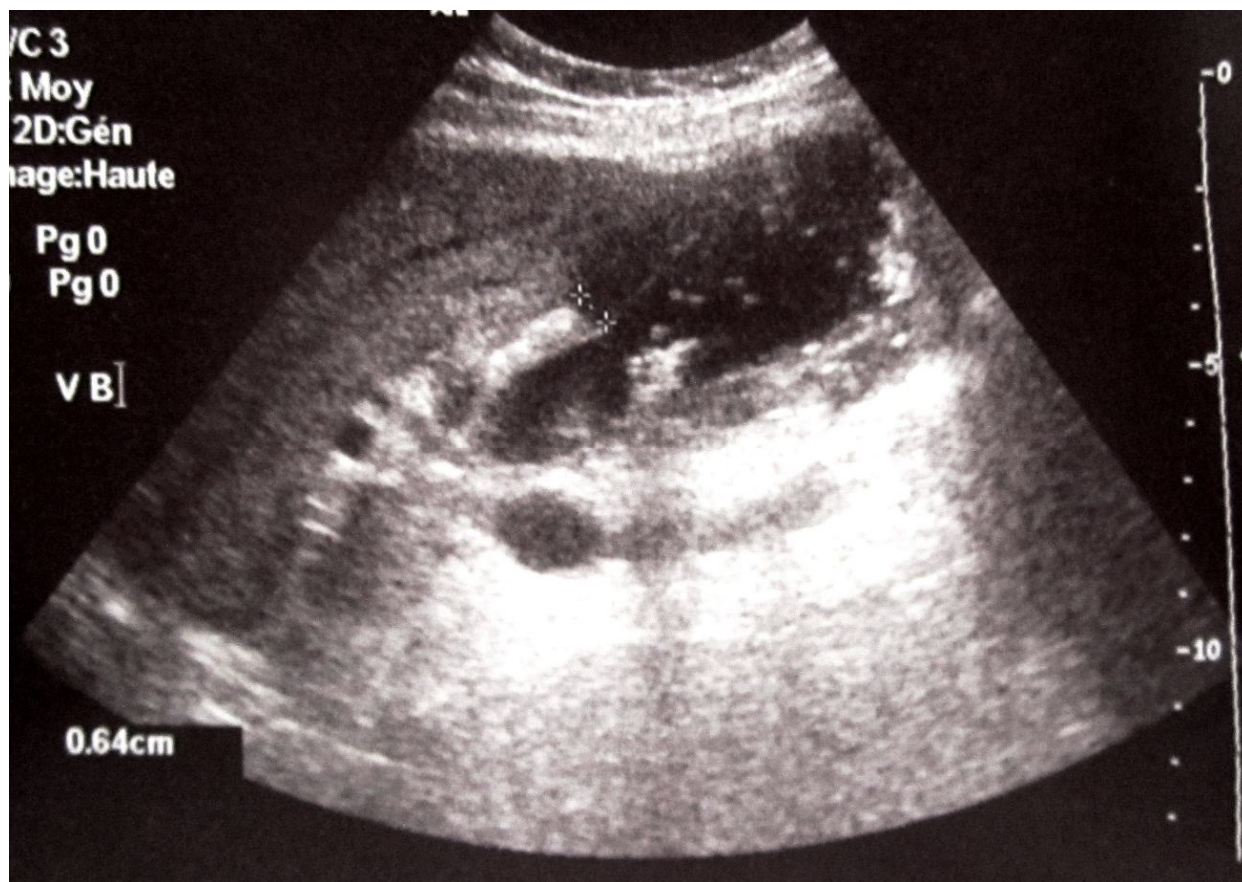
Abdominal ultrasonographic examination displaying multiple gallstones with evidence of gallbladder wall thickening (6,4 mm).
